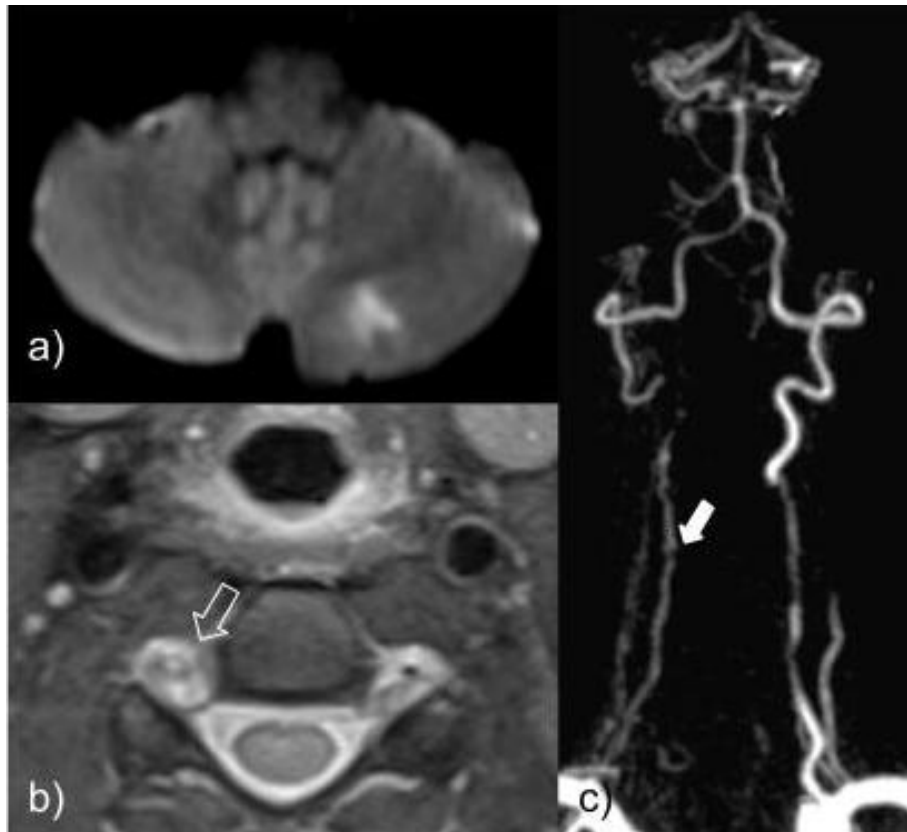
MRI and AngioMRI of patient 1. a) Acute ischemic stroke in the left cerebellum hemisphere. b) T2 image showing a hematoma filling the right C5-C6 foramina (arrow). c) Reconstruction showing the dissection of both vertebral arteries, and the corresponding level of the right C5-C6 foramina (filled arrow)
